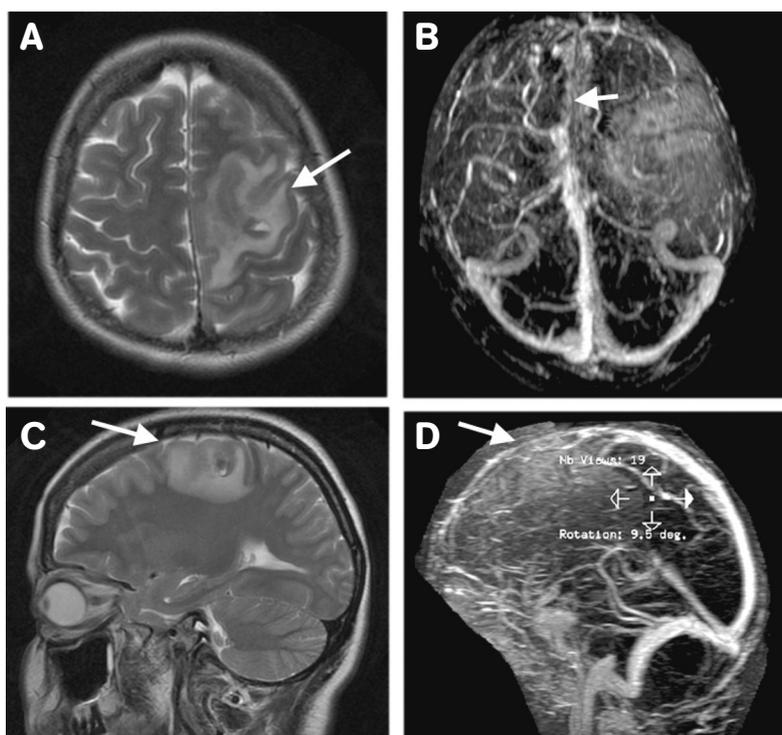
T2-weighted MRI shows venous infarction and hemorrhage in the left posterior frontal region. (A, C). MRV shows superior sagittal sinus thrombosis (arrows) and left posterior frontal cortical vein thrombosis with engorged cortical veins (B, D).
